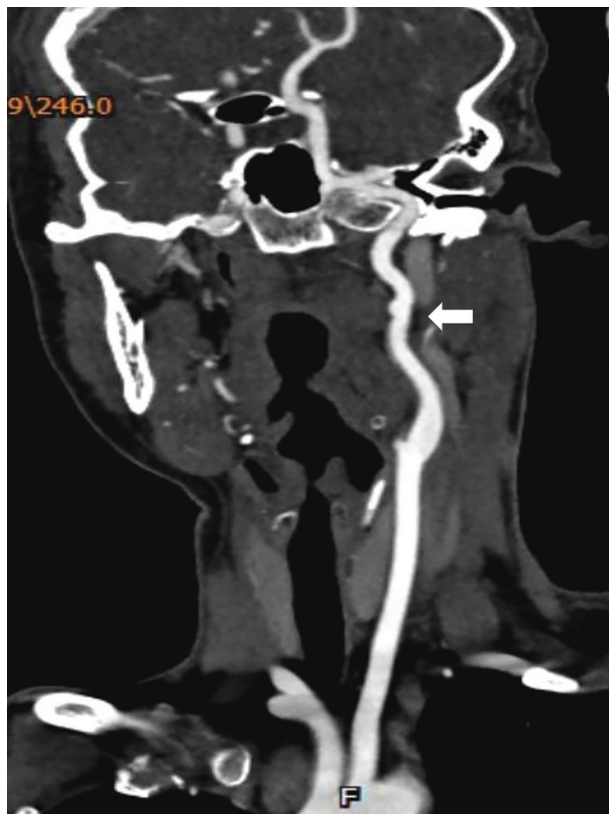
CT angiogram of the head/neck. Arrows indicate uneven thickness in the starting segment of the left internal carotid artery.
